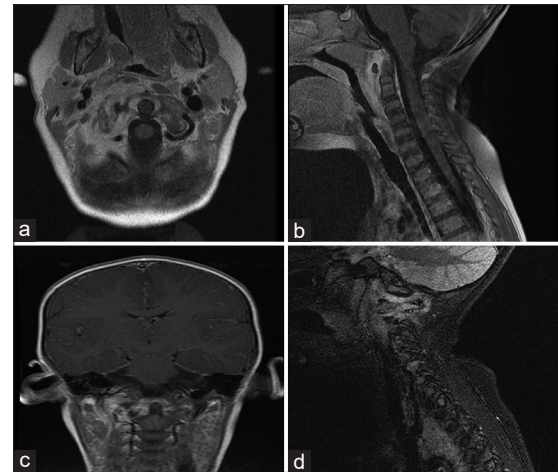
Preoperative magnetic resonance T1-weighted imaging with gadolinium contrast (a) axial view, (b) sagittal view, (c) coronal view and (d) sagittal view with short TI inversion recovery showing osteolysis of the C1 vertebra with prevertebral soft tissue mass extending from the level of odontoid process to C4 as well as alignment of cervical vertebrae with an increase in inflammatory soft tissue changes
